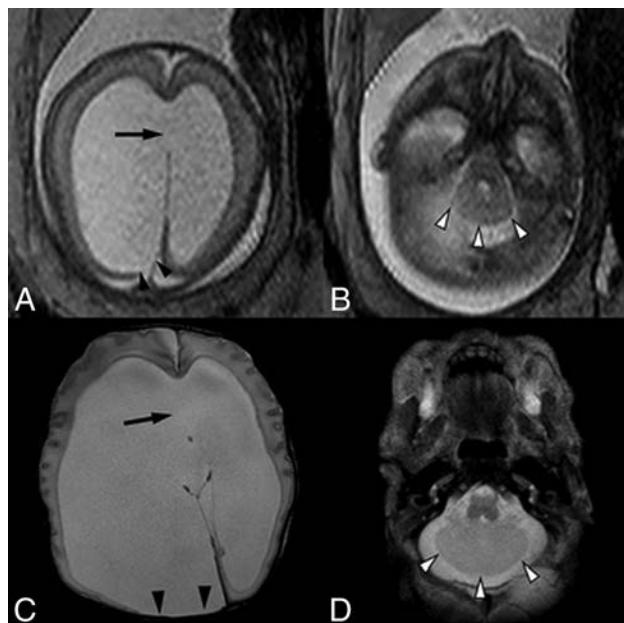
A single-shot fast spin-echo sequence in the axial planes (A and B) through the fetal head in a 23-week fetus and postnatal axial T2-weighted sequence (C and D) demonstrate asymmetric lateral ventriculomegaly with focal parenchymal disruption resulting in a posterior ventricular diverticulum (black arrowheads). Note also performance of the septum pellucidum in A and C (arrow). Within the posterior fossa (B and D), there are a small transverse cerebellar diameter, absence of the cerebellar vermis, midline fusion of cerebellar folia, and a convex posterior cerebellar contour (white arrowheads), compatible with rhombencephalosynapsis.
